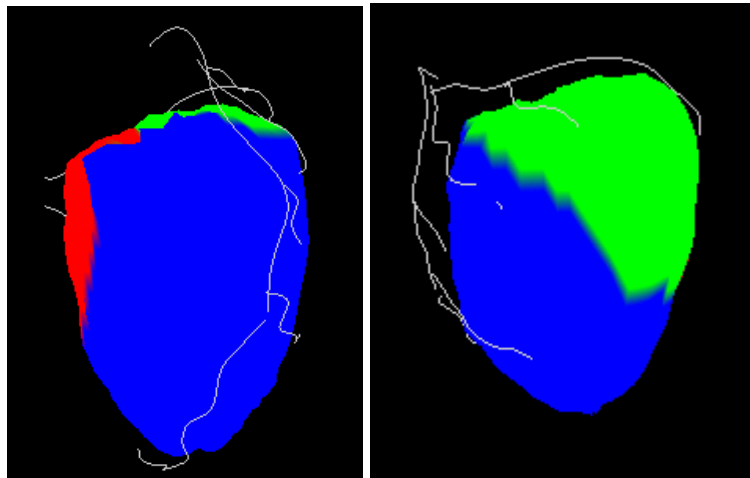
Color coded coronary territories for patient 4 over LV model from CTA, with 3 coronaries: LAD (blue), LCX (green) and RCA (red).
